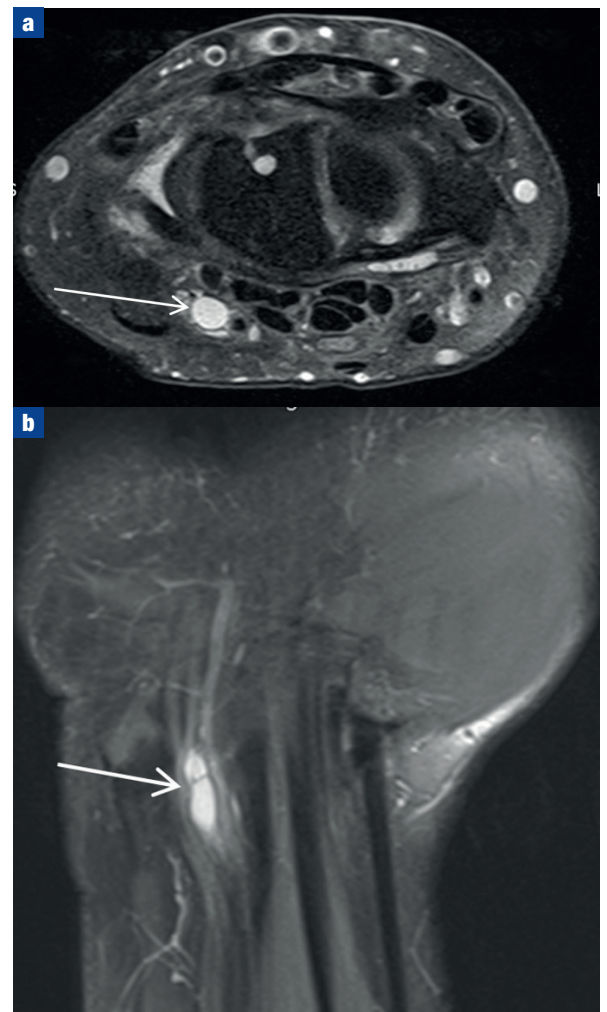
Magnetic resonance imaging short tau inversion recovery (STIR) sequence of the wrist. a. Axial image demonstrating a high signal ganglion cyst in Guyon's canal impinging the ulnar nerve (arrow). b. Coronal image demonstrates a bi-lobed ganglion cyst in Guyon's canal impinging the linear ulnar nerve (arrow) on the ulnar aspect of the wrist.
